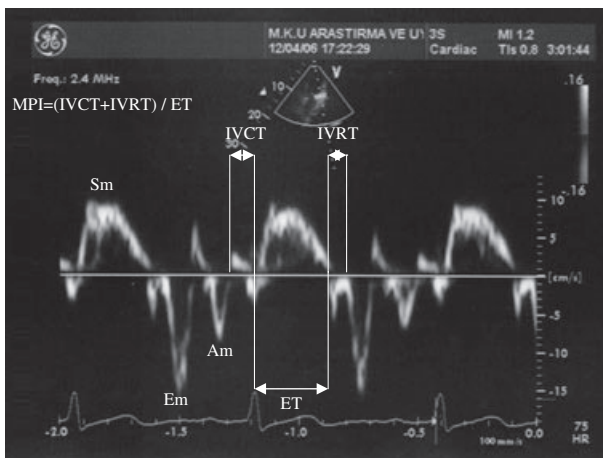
Time intervals of the myocardial performance index (MPI) derived with pulsed wave tissue Doppler echocardiography. MPI was calculated as the sum of isovolumic contraction time (IVCT) and isovolumic relaxation time (IVRT) divided by ejection time (ET).
